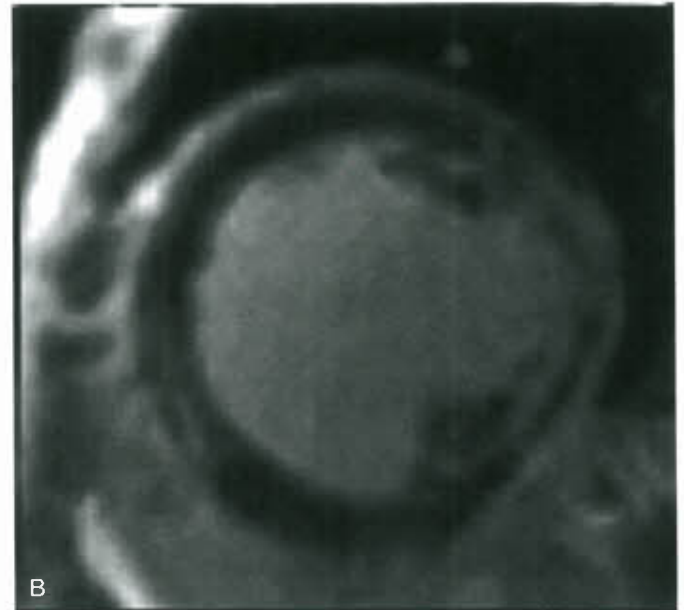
MRI from same patient as in Figures 59.2 and 59.3 (Courtesy of Stephen Cook, MD.). A: Note that fibrosis (white appearance) posterior to the mitral papillaries has nearly completely replaced muscle. B: Fibrosis extends through the myocardium. Functional information was similar to the echo results.
